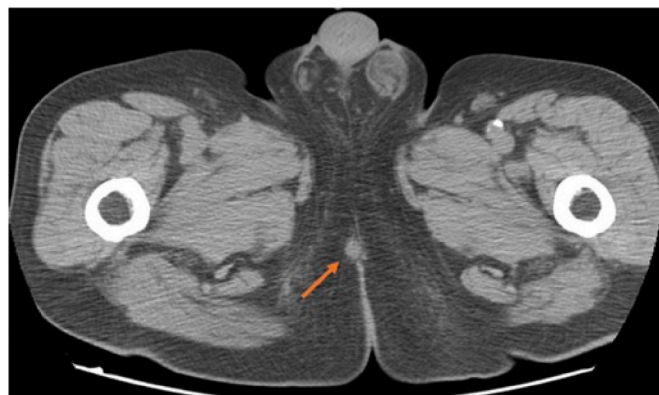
Axial CT pelvis performed two years prior to ^{18}F -FCH PET-CT. A small perineal nodule is visible (arrow).
